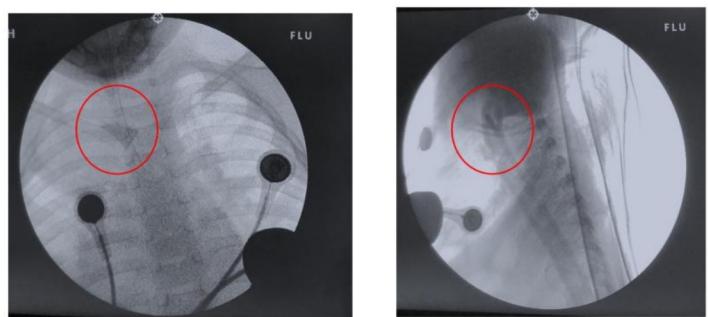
Intraoperative radiograph revealing the presence of the foreign body at the level of T1-T2
